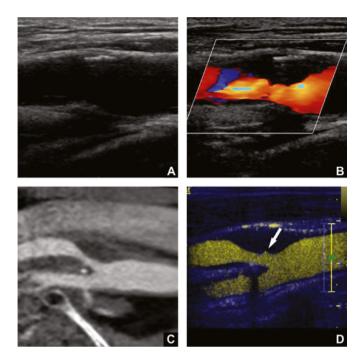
Longitudinal images of carotid plague classified as ulcerated with CEUS and smooth with CTA. Longitudinal B-mode ultrasound (A), CDUS (B), CTA (C), and CEUS (D). A hypoechoic plaque was present in the near wall of the carotid artery, the full extent of which was not visible on B-mode ultrasound (A). CDUS (B) provided improved visualization of the plague size but did not identify an ulcer. (D) CEUS demonstrated a small ($\approx 1 \times 2$ mm) ulcer (arrow) not visible using CDUS or CTA (C).
